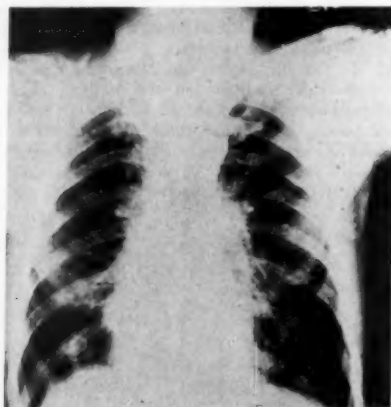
Case 7. Postero-anterior X-ray. Pleural sequestration cyst at the right apex.
